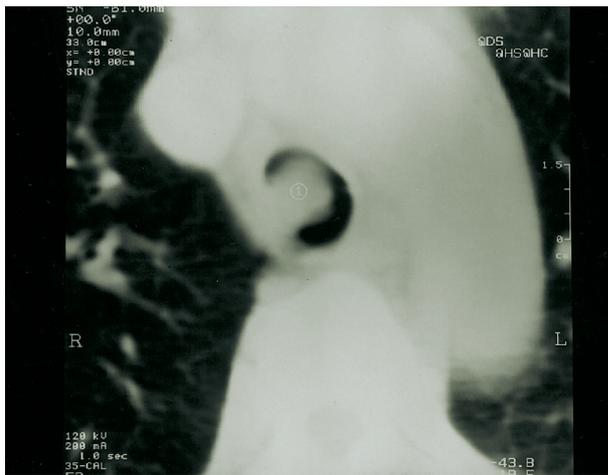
Chest CT revealing a tracheal tumor above the carina.
